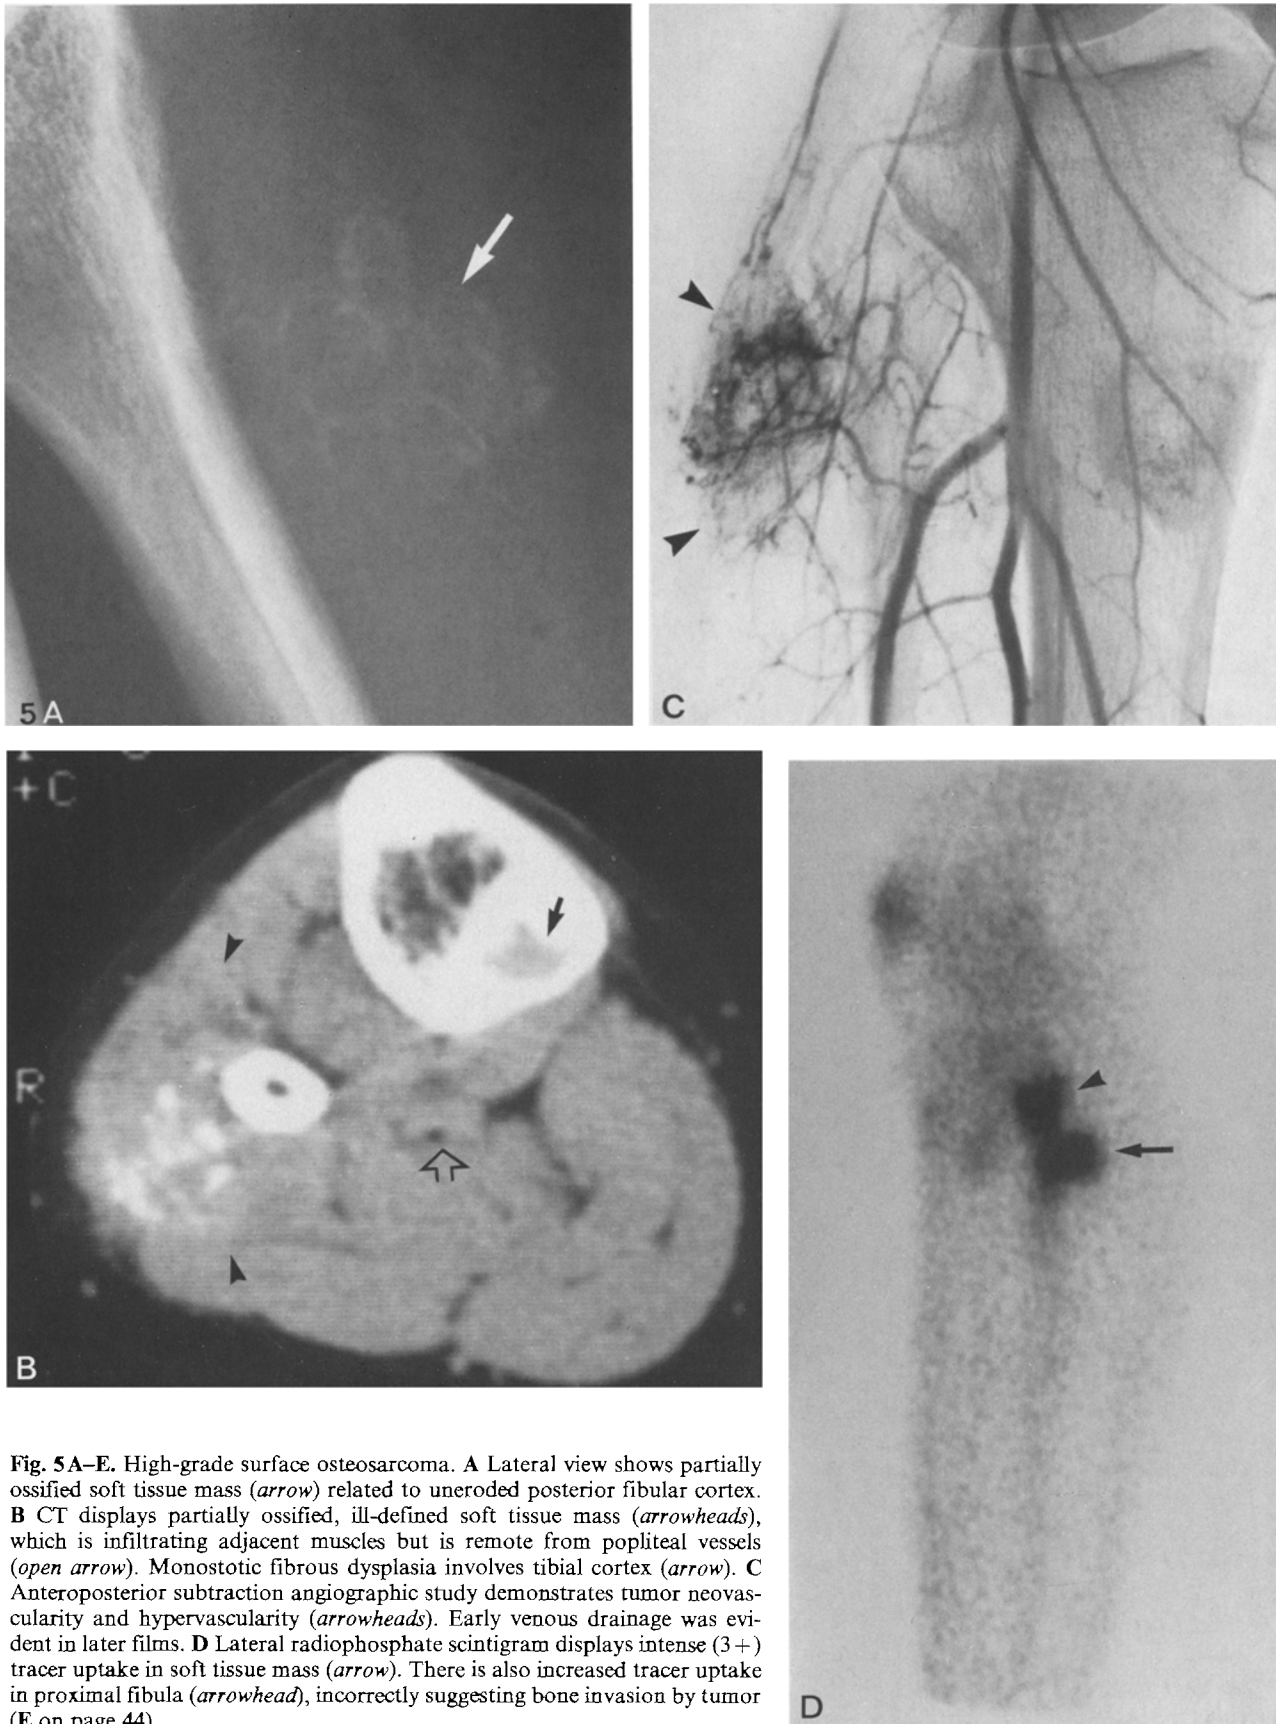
High-grade surface osteosarcoma. A Lateral view shows partially ossified soft tissue mass (*arrow*) related to uneroded posterior fibular cortex. B CT displays partially ossified, ill-defined soft tissue mass (*arrowheads*), which is infiltrating adjacent muscles but is remote from popliteal vessels (*open arrow*). Monostotic fibrous dysplasia involves tibial cortex (*arrow*). C Anteroposterior subtraction angiographic study demonstrates tumor neovascularity and hypervascularity (*arrowheads*). Early venous drainage was evident in later films. D Lateral radiophosphate scintigram displays intense (3+) tracer uptake in soft tissue mass (*arrow*). There is also increased tracer uptake in proximal fibula (*arrowhead*), incorrectly suggesting bone invasion by tumor (E on page 44).
